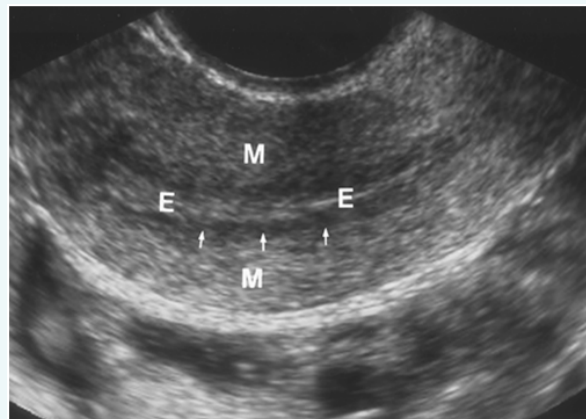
Normal ultrasound appearance of the endometrium (E) and myometrium (M). Arrows = innermost layer of myometrium or subendometrial halo. From RadioGraphics, 19, S147-S160.
